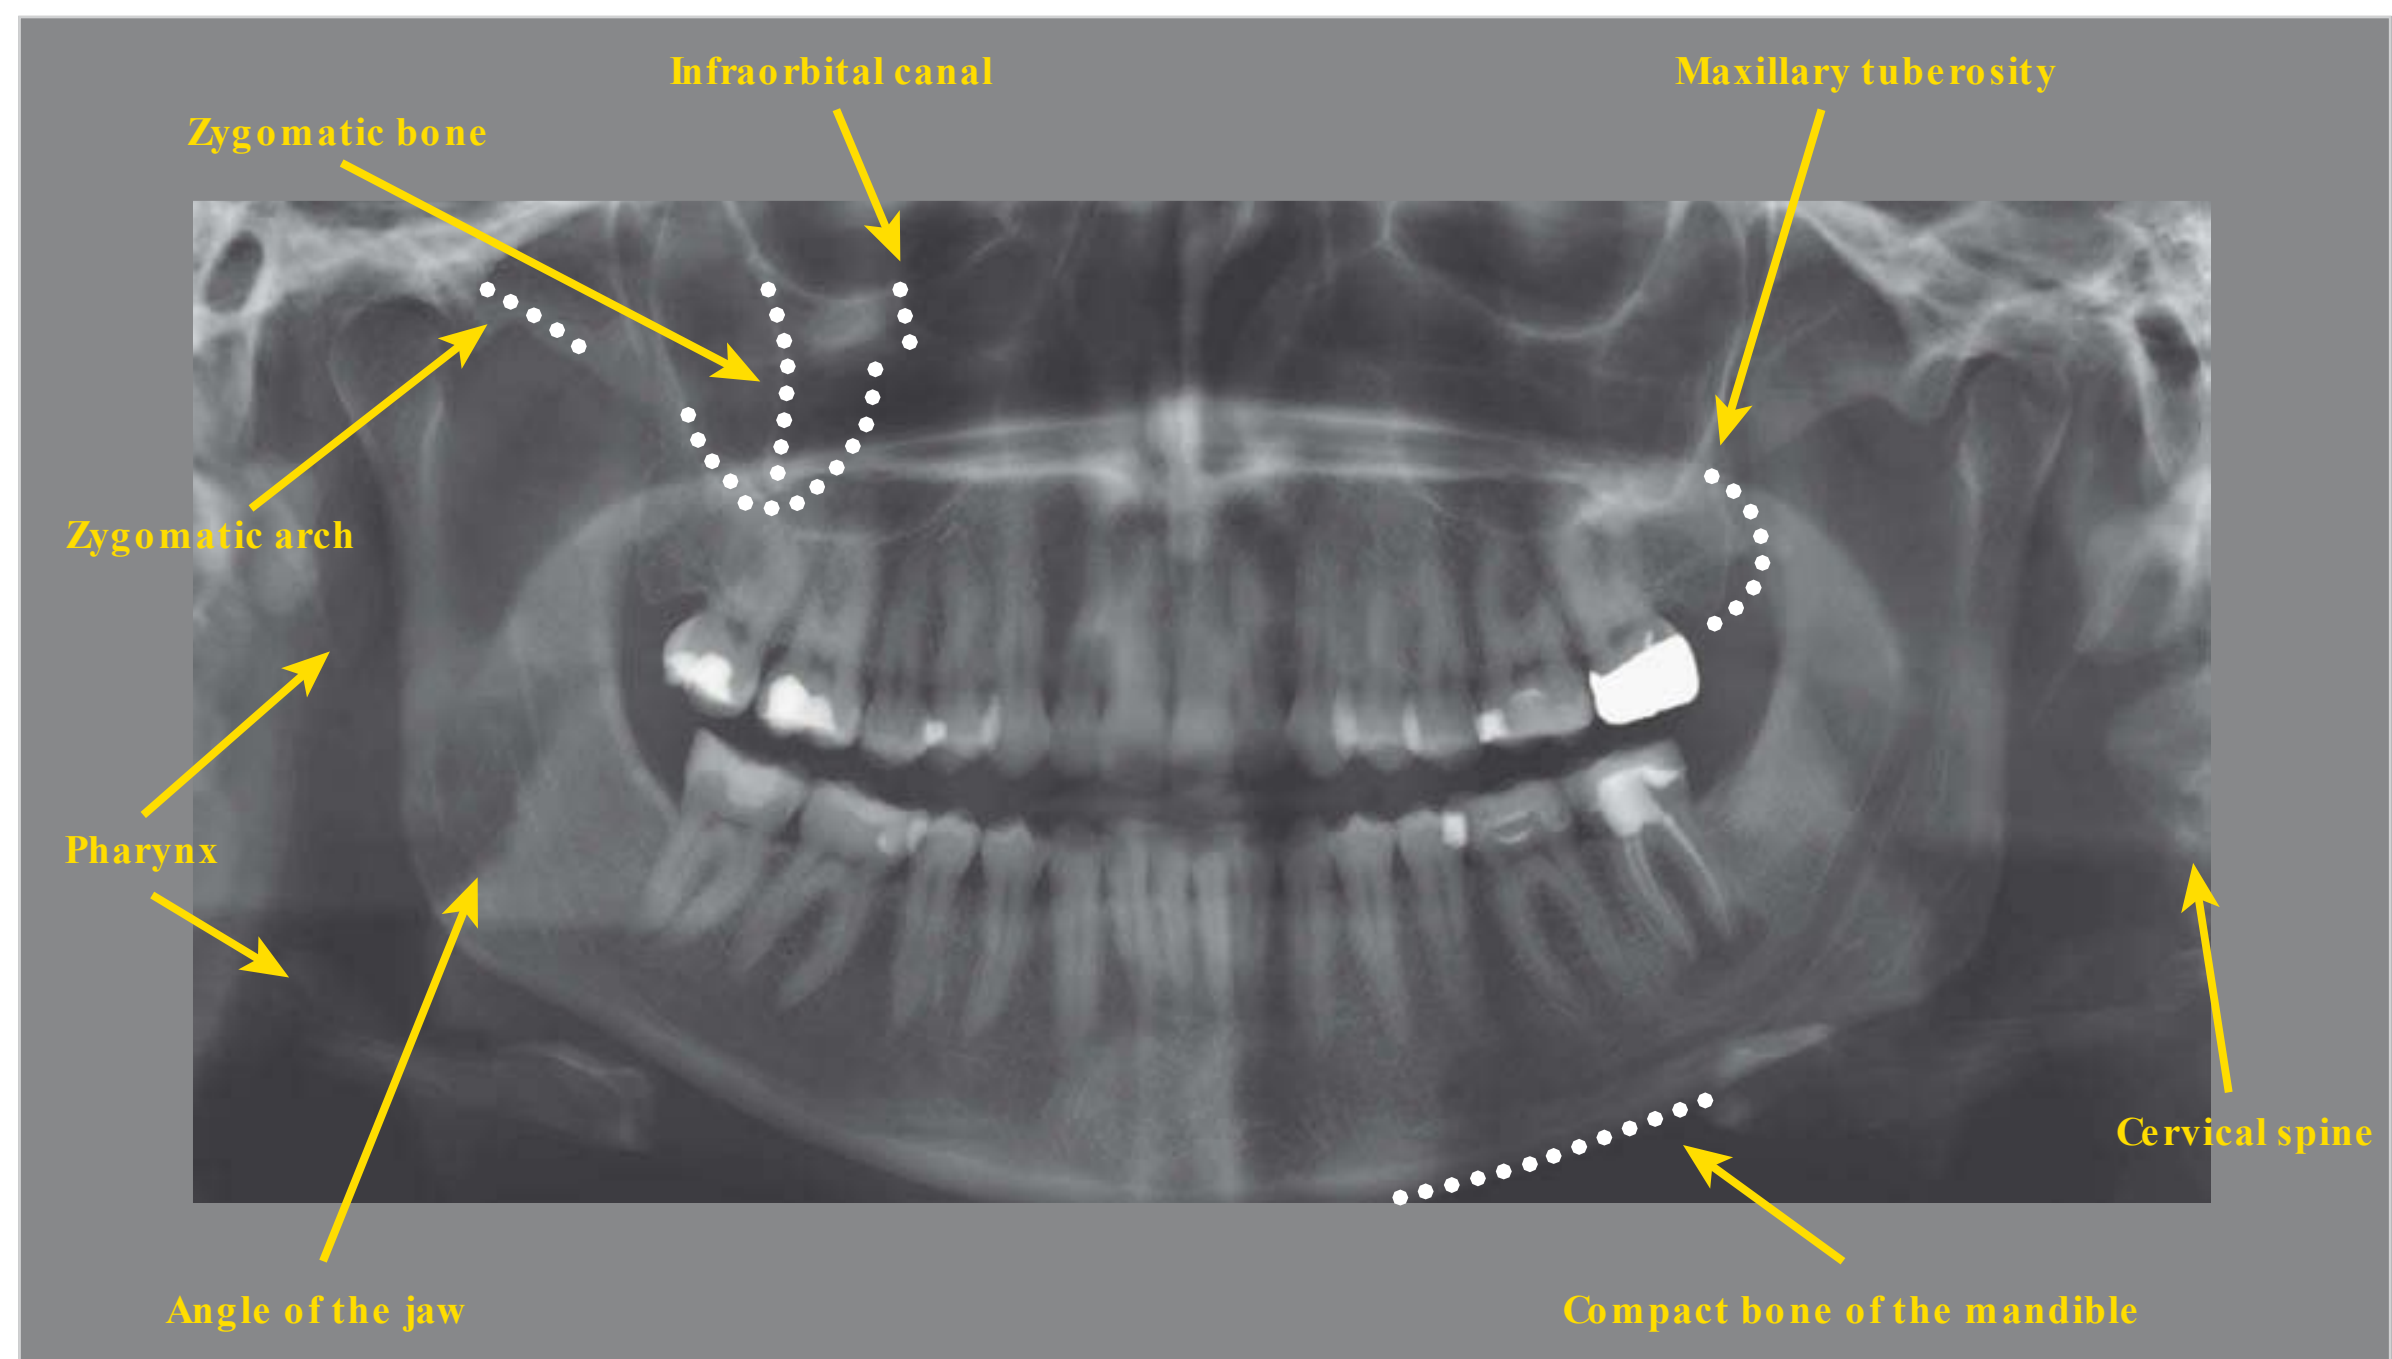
Panoramic radiography: anatomical structures IV.
